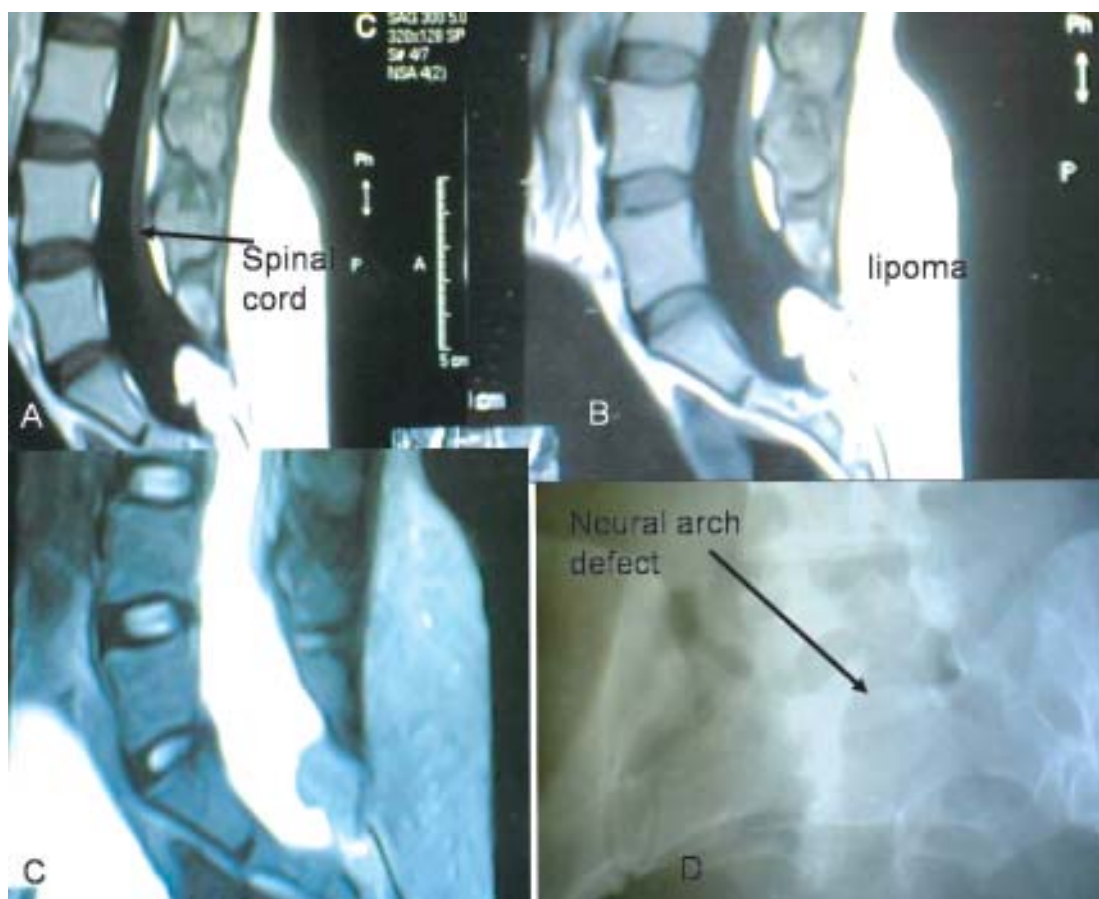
MRI of lumbo-sacral spine, A & B-T1 weighted sagittal image, C-T2 weighted image showing low attached spinal cord with intra and extradural lipoma, D-Plain x-ray lumbo-sacral spine showing neural arch defect
